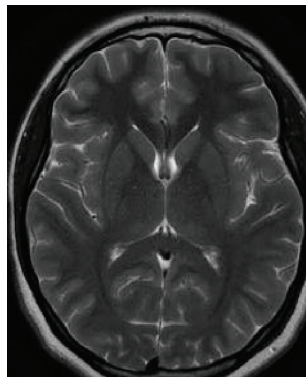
MRI of brain at 25 months of age, Slight symmetrical cortical atrophy
